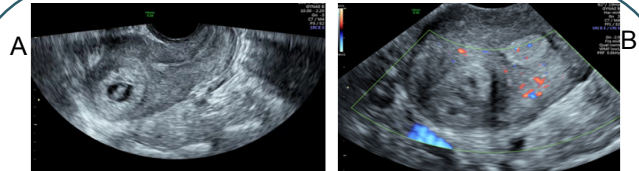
A shows ultrasound image identifying a cornual ectopic pregnancy separate from the endometrium with thin surrounding myometrium. B shows evidence of the resolving ectopic pregnancy mass with absence of vascularity.
